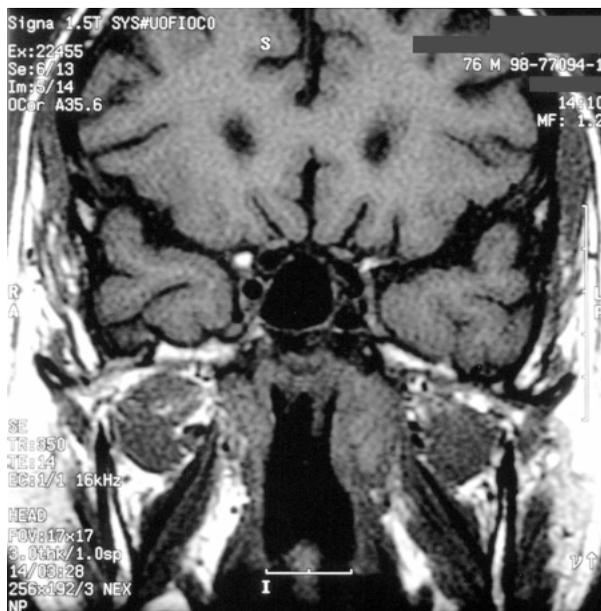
Coronal T1-weighted magnetic resonance imaging scan of the case patient shows an aggressive infiltrative edematous process invading the skull base. The process appears to be centered on the left high carotid space and is consistent with aggressive mastoiditis with extensive inflammation and granulation. The inflamed area measures roughly $3 \times 3 \times 5.5$ cm.
